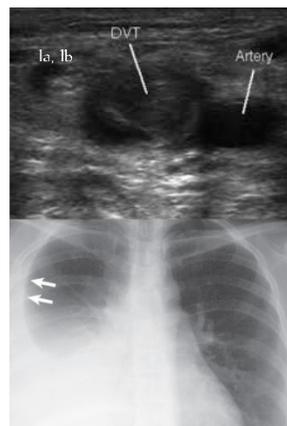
Leg Doppler and Chest X-Ray
